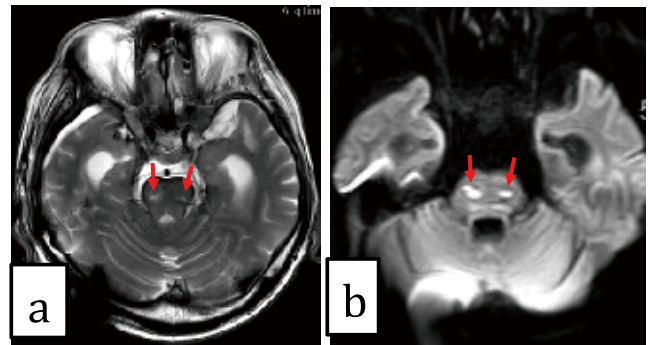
Magnetic resonance imaging findings five days after ICU discharge. Magnetic resonance imaging demonstrated a central hyperintense lesion within the pons on T2- (Figure 3a) and diffusion-weighted imaging (Figure 3b), which indicated central pontine myelinolysis (red arrows).
